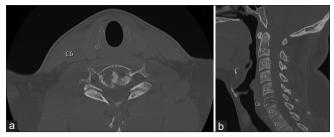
Preop CT axial (a) and sagittal (b) view showing comminuted compression deformity of C6 vertebral body with 50-55% height loss and retropulsion of bony fragments into the spinal canal.
